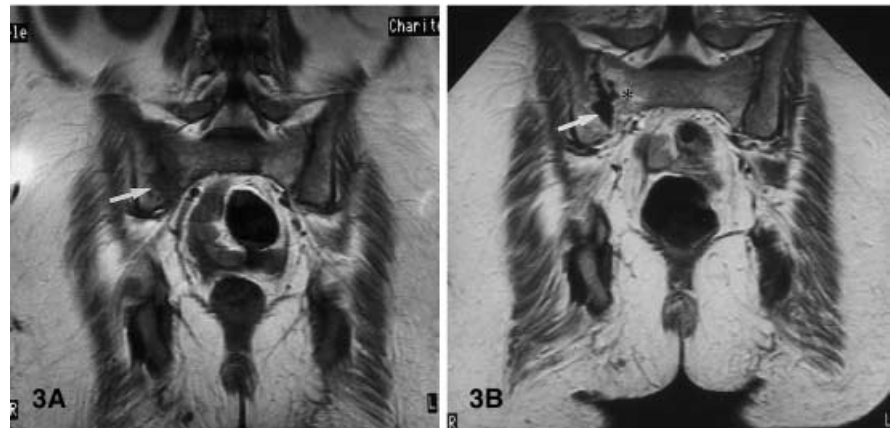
Case 5. Coronal precontrast (A) and postcontrast (B) and axial (C) postcontrast T1-weighted images (SE; TR/TE: 500/15 ms) of a 41-year-old patient who developed septic sacroiliitis with abscess formation and joint edema secondary to tonsillitis 60 days earlier. A bizarre abscess cavity is demonstrated with erosive destruction of the joint (*small arrow*) (A–C), which is surrounded by contrast-enhancing granulation tissue (*asterisk*) (A). Infiltration is seen destroying the capsule and extending into the subperiosteal area of the ilium and into the iliac muscle (*large arrow*) (C)
